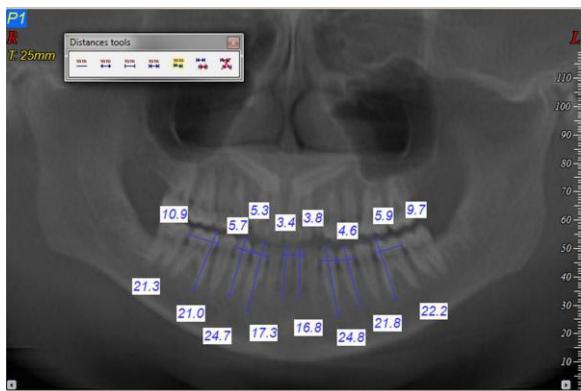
Tooth size measurements in CBCT reconstructed panoramic view
